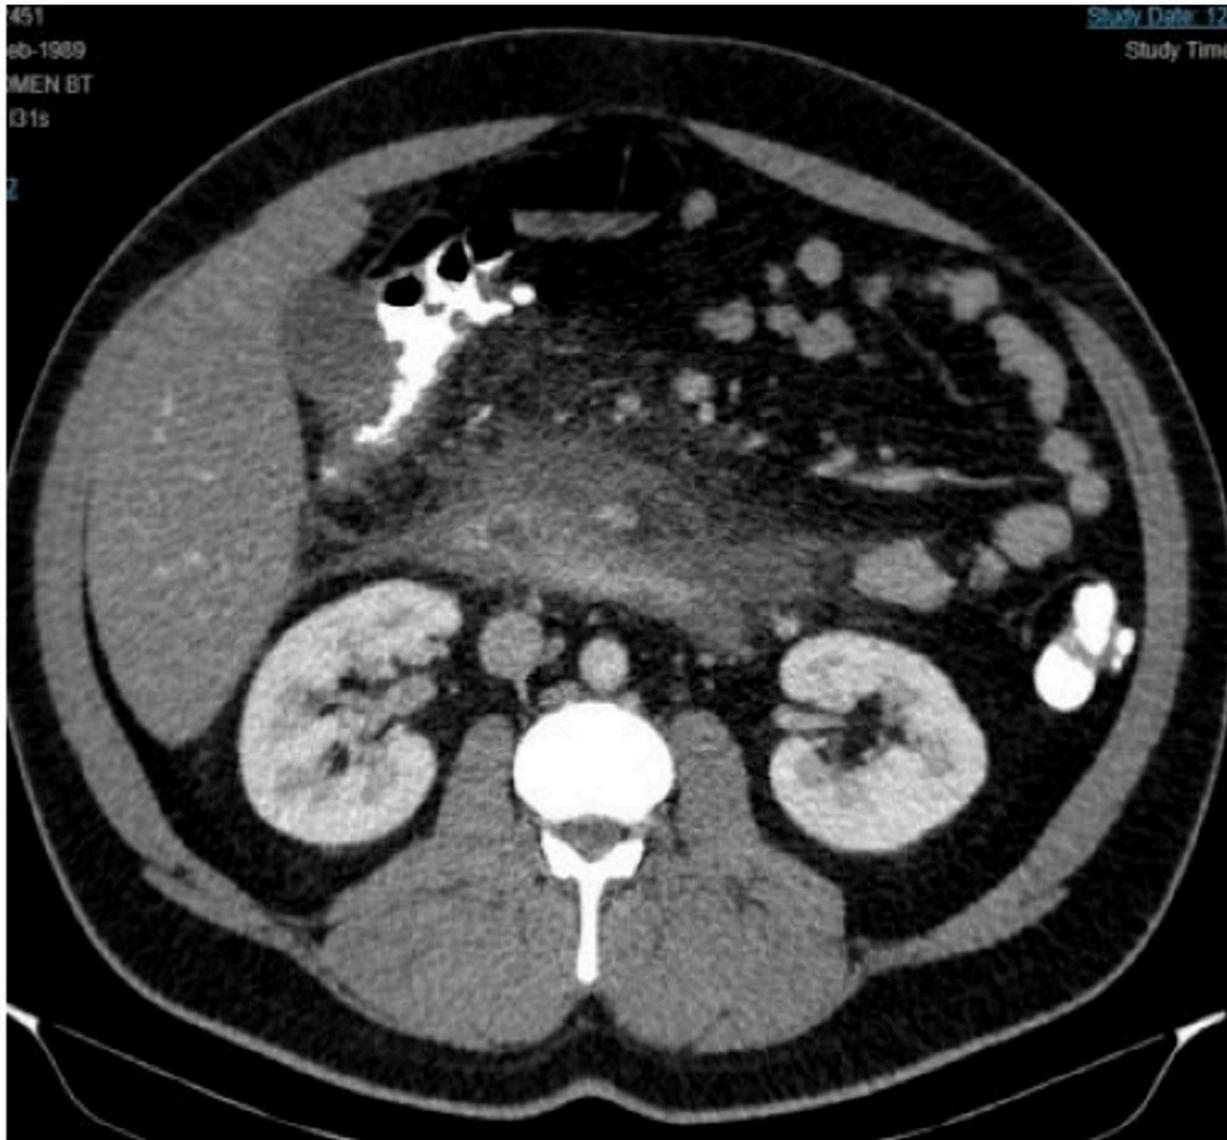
Patient's computed tomography indicating acute pancreatitis.
